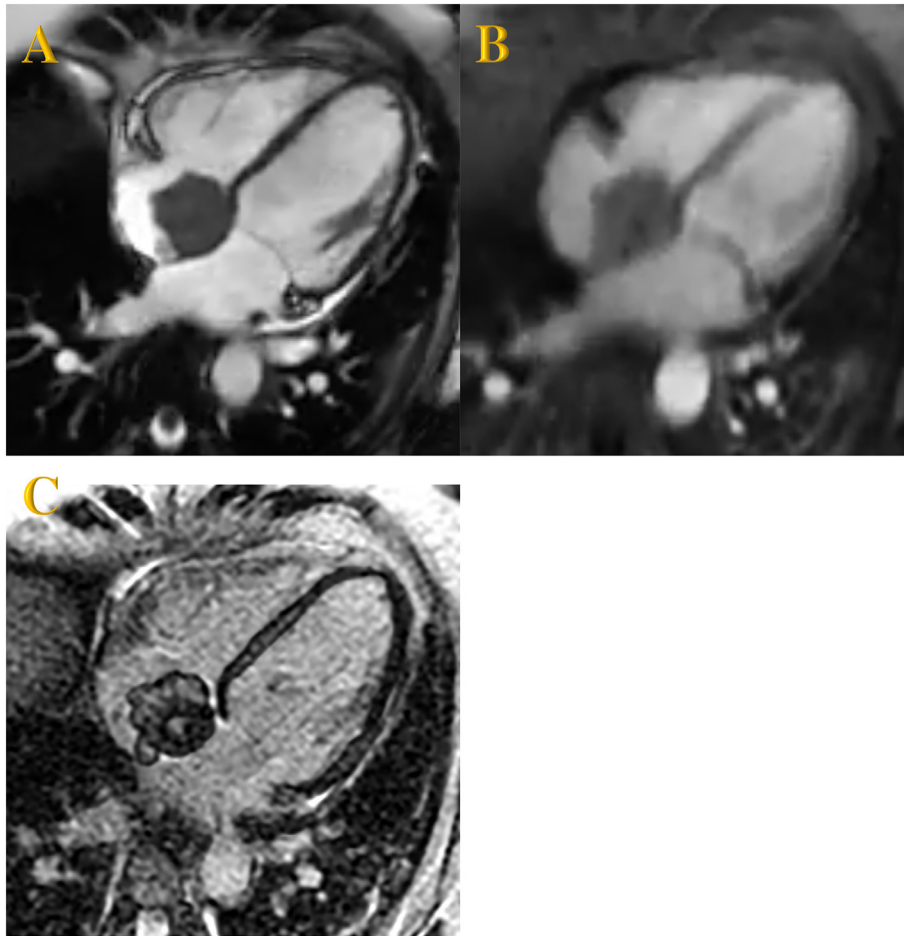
A  $30 \times 18$  mm large mass appears to be attached/adjacent to the interatrial septum on echocardiography. The mass is isointense on bright blood sequence (image A) and has heterogeneously high signal on T2-weighted sequence (image B). There is poor contrast uptake on first-pass images (image C) and no enhancement on delayed enhance sequence (image D with breathing motion artifact limitation). Dark signal on long TI (600 ms) sequence (image E) confirms lack of enhancing tissue. These findings are consistent with a subacute thrombus.
